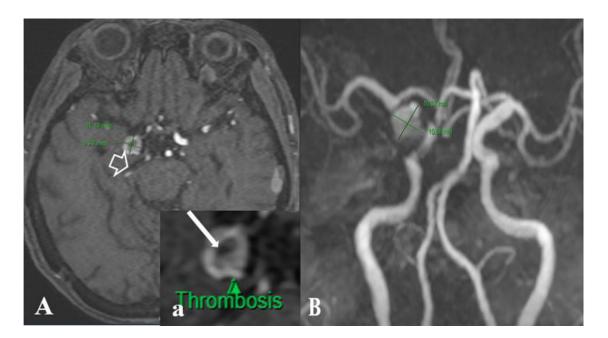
Brain MRI images on the 45th day after the endovascular treatment. (A) Phase-contrast MRI measurements showed aneurysm with its size: 11.1×9.2 mm and partial thrombosis, (B) a right internal carotid aneurysm.
